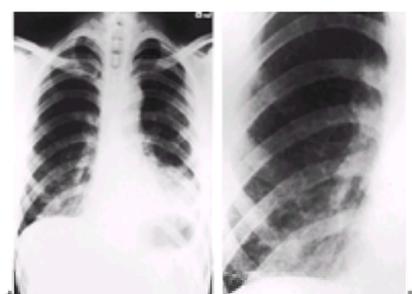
Chest radiograph of a subject with acute silicosis. Panel A: Acinar filling pattern in both lower zones and in the left lateral chest. The extensive soft shadowing seen in acute silicosis is more often seen in the upper zones. Panel B: Detail of a right lower lung zone containing an acinar filling pattern with scanty irregular opacities.
